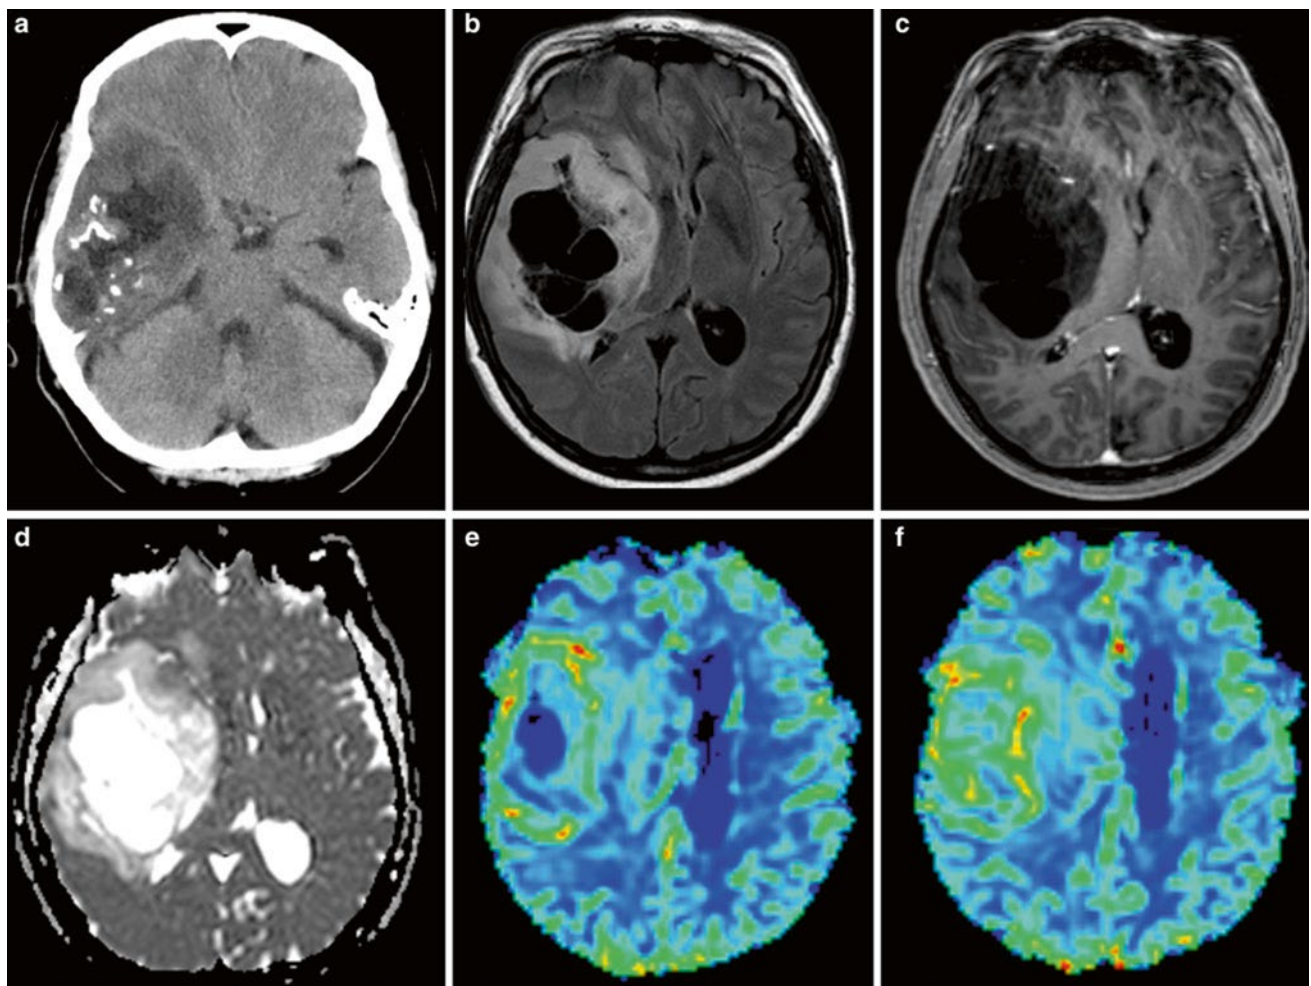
Oligodendroglioma, an example for an atypical low-grade glioma: *upper row* (a) axial nonenhanced CT, (b) FLAIR, and (c) post-Gd T1w image; *lower row* (d) ADC map, (e, f) DSC rCBV map in a right
